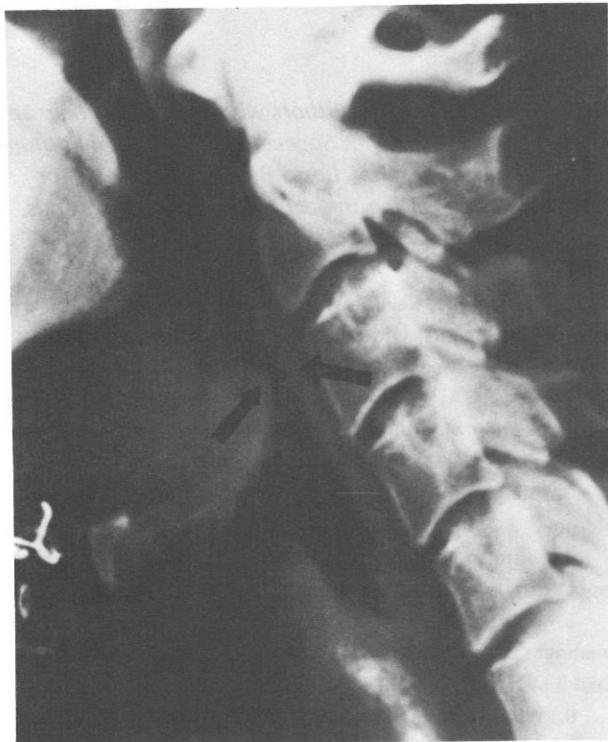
Soft-tissue radiograph, a lateral-neck view, demonstrates the occluded oropharynx.
